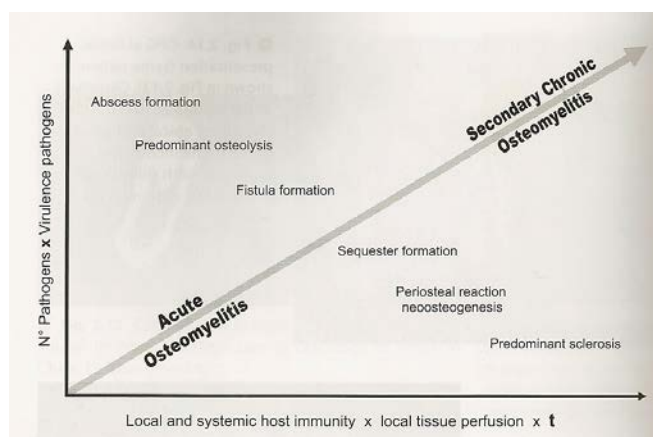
The formation of certain clinical and radiographic findings is dependent on the intensity of the disease and the magnitude of imbalance between the host and the microbes, as well as the time frame
